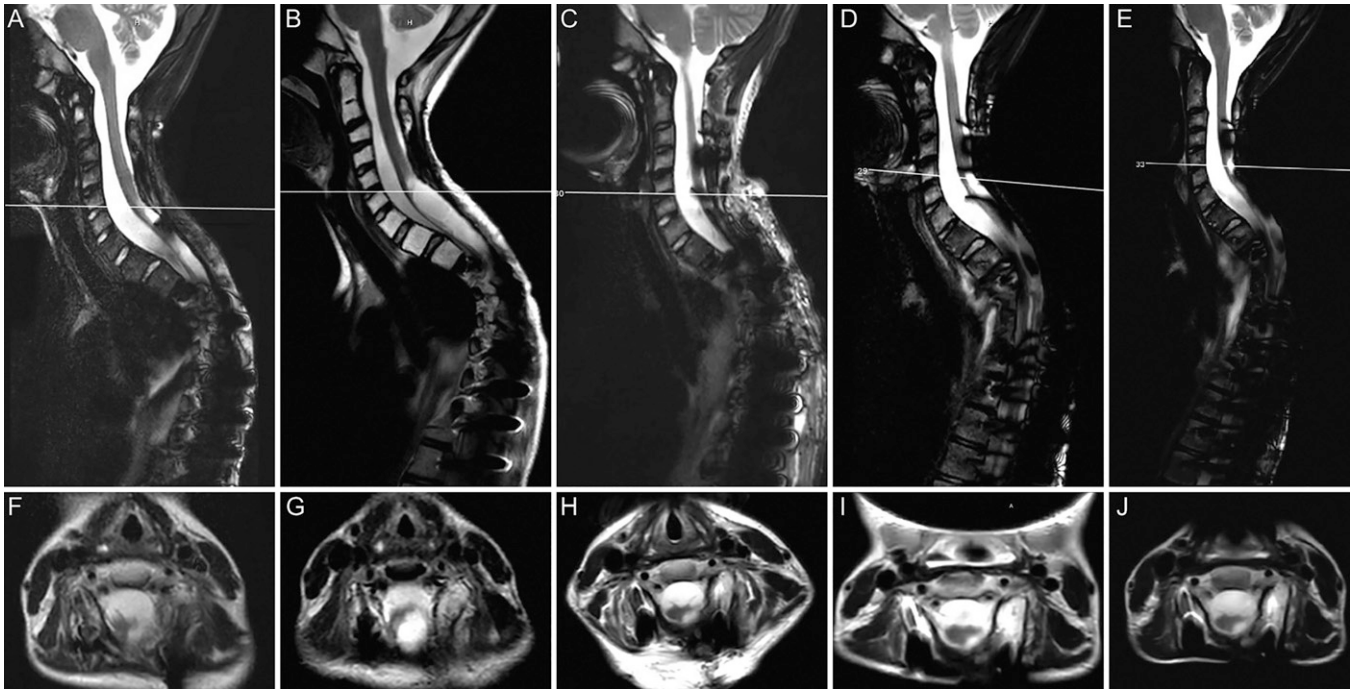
Sagittal and axial T2-weighted MRI. A and F: After initial spinal fusion. B and G: After pseudarthrosis, instrumentation failure, and worsening of deformity. C and H: Postoperative day 1 after revision deformity correction. D and I: Postoperative 6-month follow-up. E and J: Postoperative 15-month follow-up.
